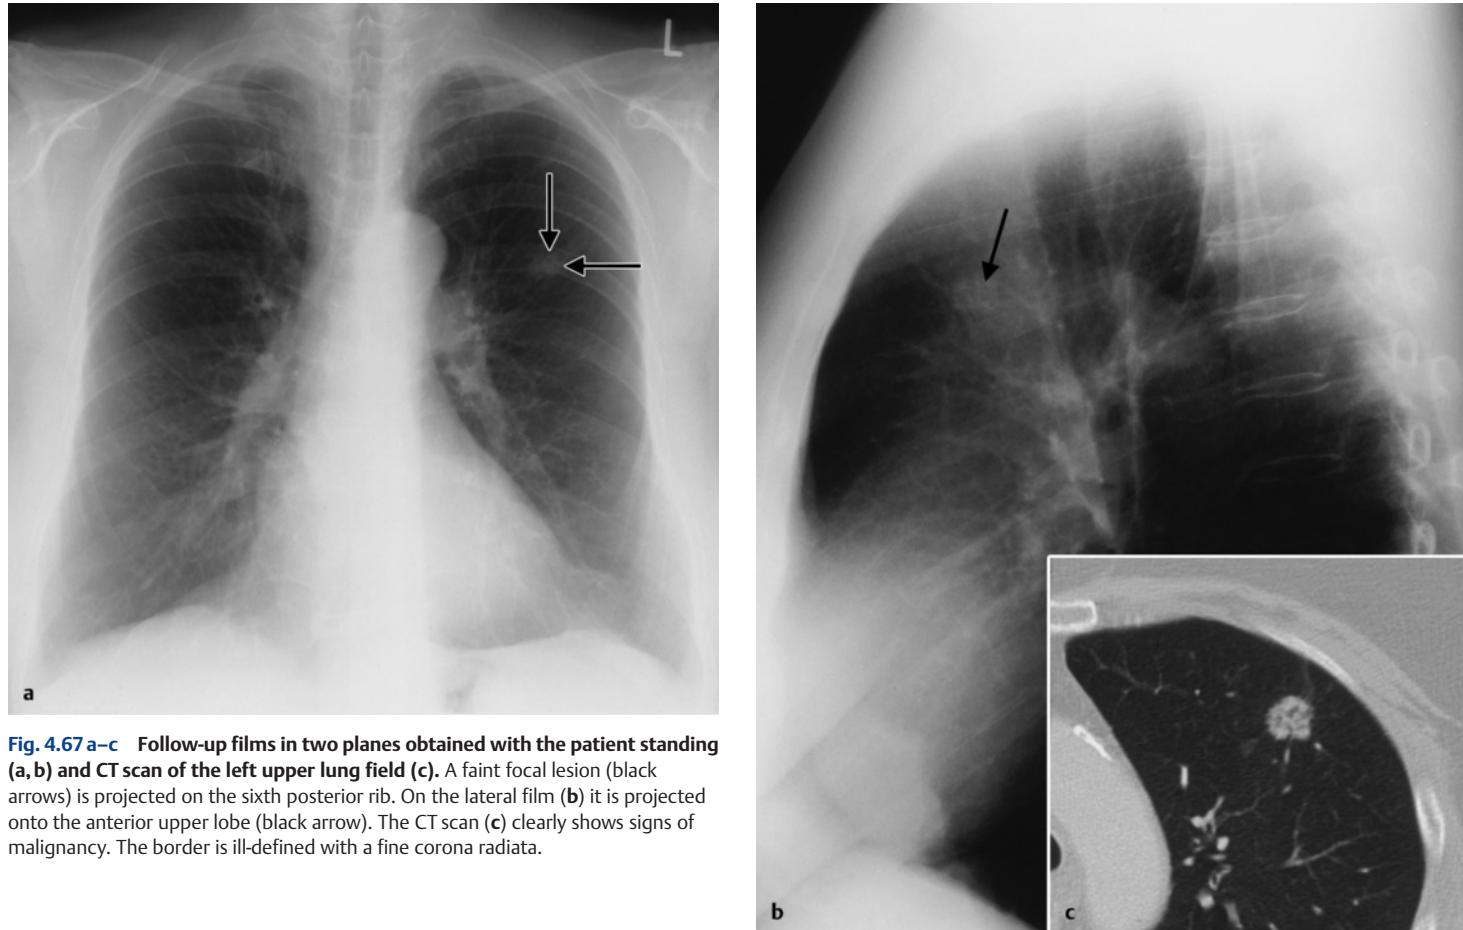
a–c Follow-up films in two planes obtained with the patient standing (a, b) and CT scan of the left upper lung field (c). A faint focal lesion (black arrows) is projected on the sixth posterior rib. On the lateral film (b) it is projected onto the anterior upper lobe (black arrow). The CT scan (c) clearly shows signs of malignancy. The border is ill-defined with a fine corona radiata.
